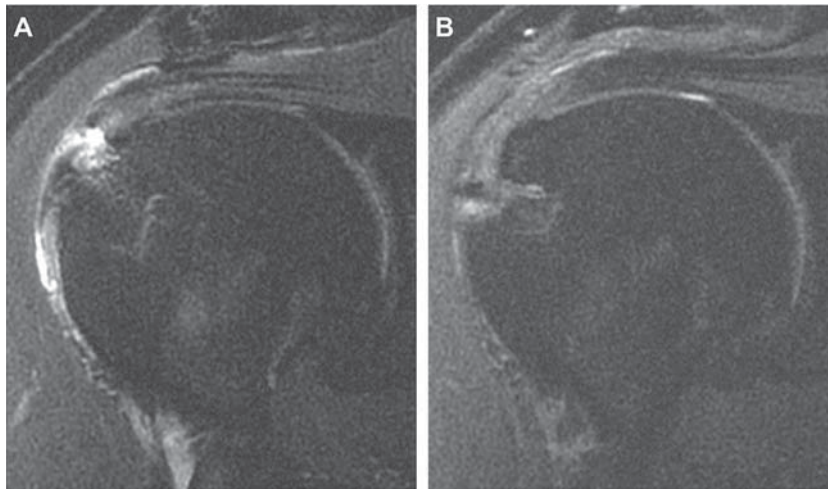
(A) Preoperative magnetic resonance image demonstrating a high-grade, bursal-sided partial-thickness defect of greater than 50% of the tendon thickness with less than 1 mm of the supraspinatus tendon intact at the lesion location. (B) One year after surgery, the thickness of the supraspinatus tendon at the defect location increased to 5.5 mm and the defect was completely healed (100% fill-in) with no visible boundary between the implant and underlying tendon.
